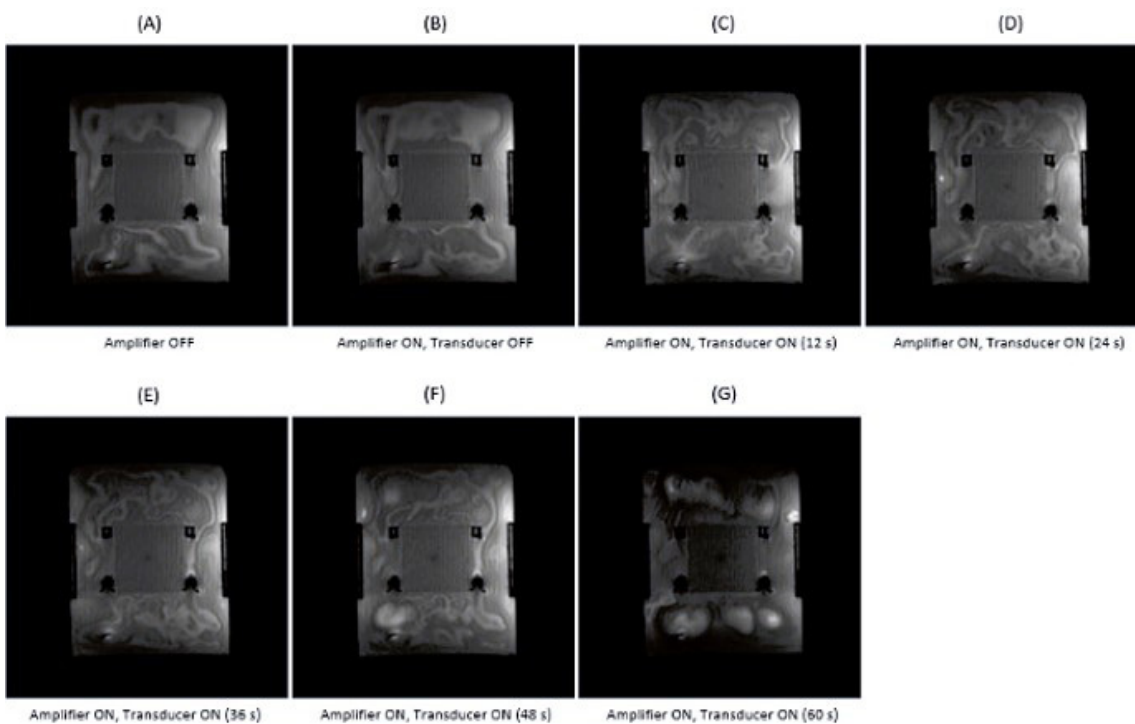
MR images acquired on coronal plane with T1-W SPGR for different transducer activation conditions.
